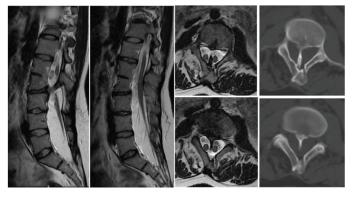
A 29-year-old female applied with complains of low back pain, sometimes right leg pain for 6 months. It was increases when leaning forward. Bilateral foot thumbs were dorsal fleksion 3/5. CT showed a bony spur extending from the lamina of L1 through the midline of the spinal canal to the posterior margin of the L1-L2 disc space. MRI showed a bisection of the spinal cord and conus medullaris were tethered to L4-5 levels
